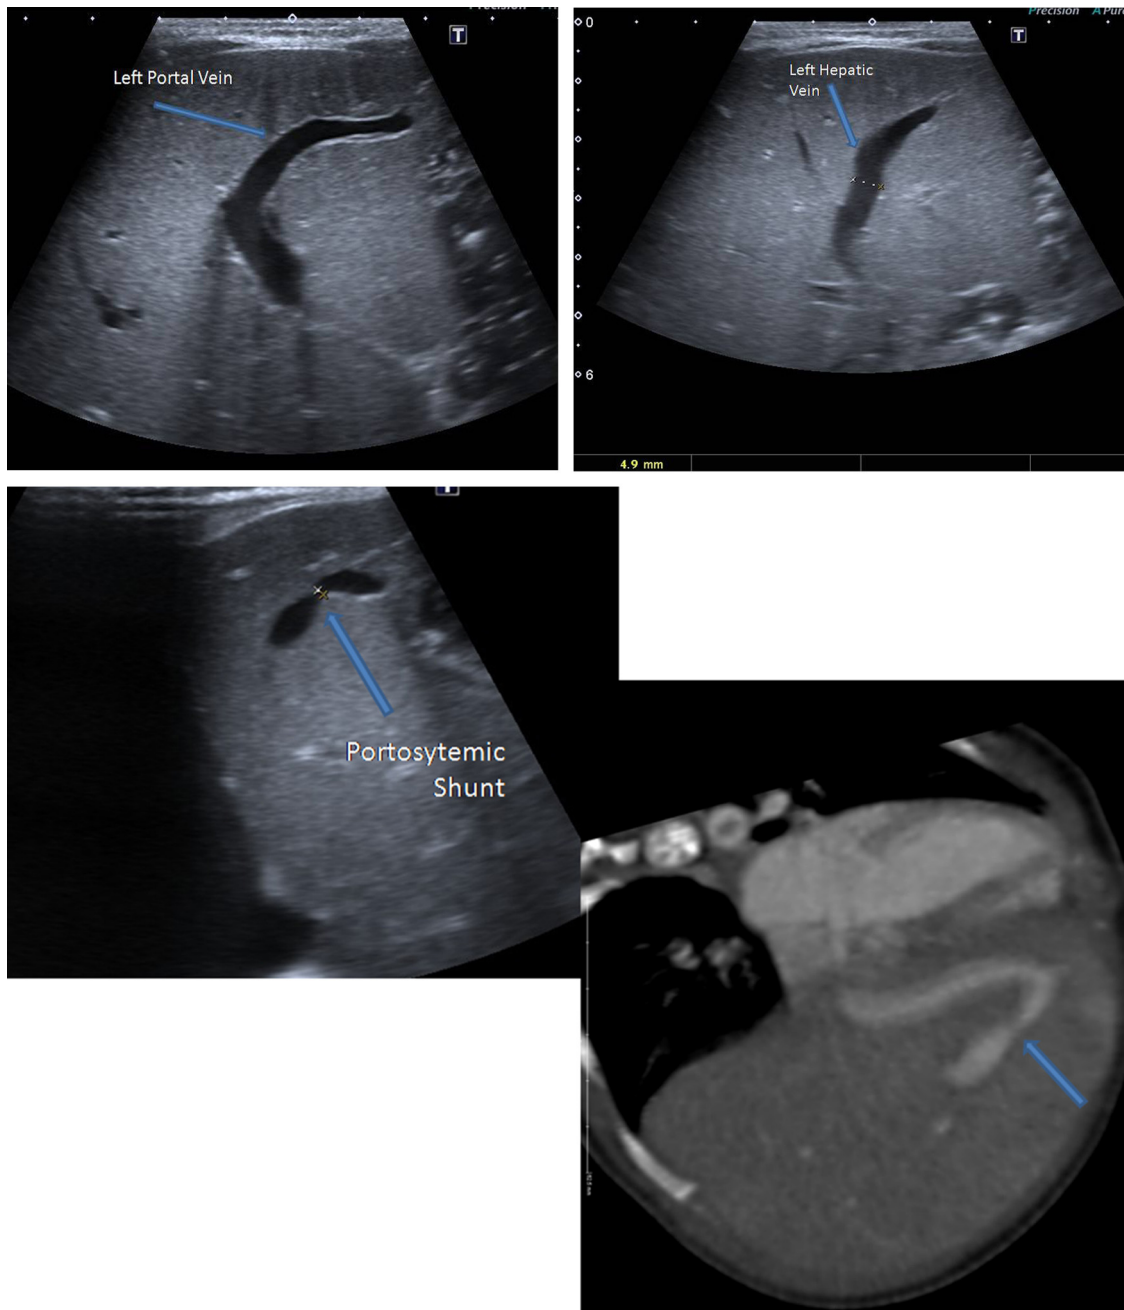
Ultrasonography and reformatted contrasted CT imaging show connection between dilated vena porta and left hepatic vein (white arrow).
